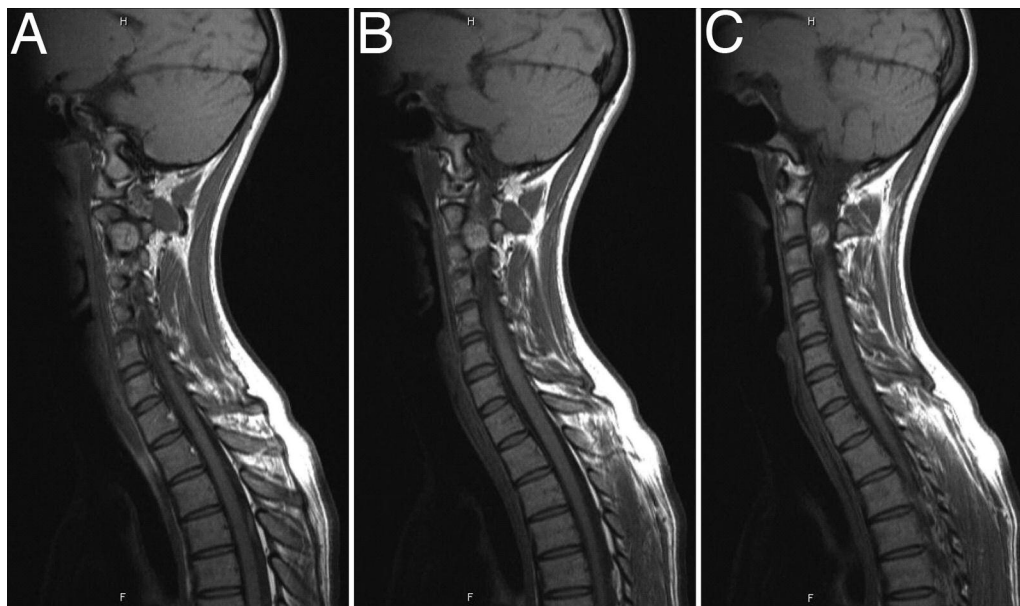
Sagittal T₁-weighted MR images showing a dumbbell-shaped C2–3 hyperintense enhancing lesion.
